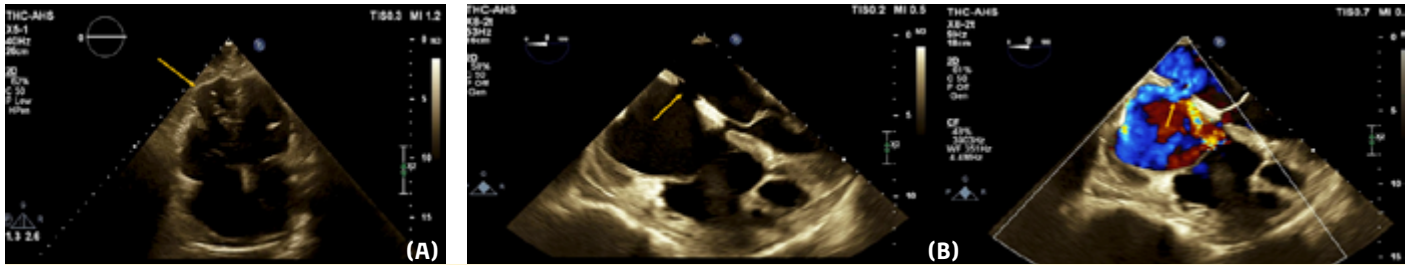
(A) Transthoracic echocardiography shows right ventricular enlargement with aneurysm formation in the right ventricular free wall in the apical four-chamber view. (B) Transesophageal echocardiography demonstrates a secundum-type atrial septal defect in the mid-esophageal four-chamber view.
